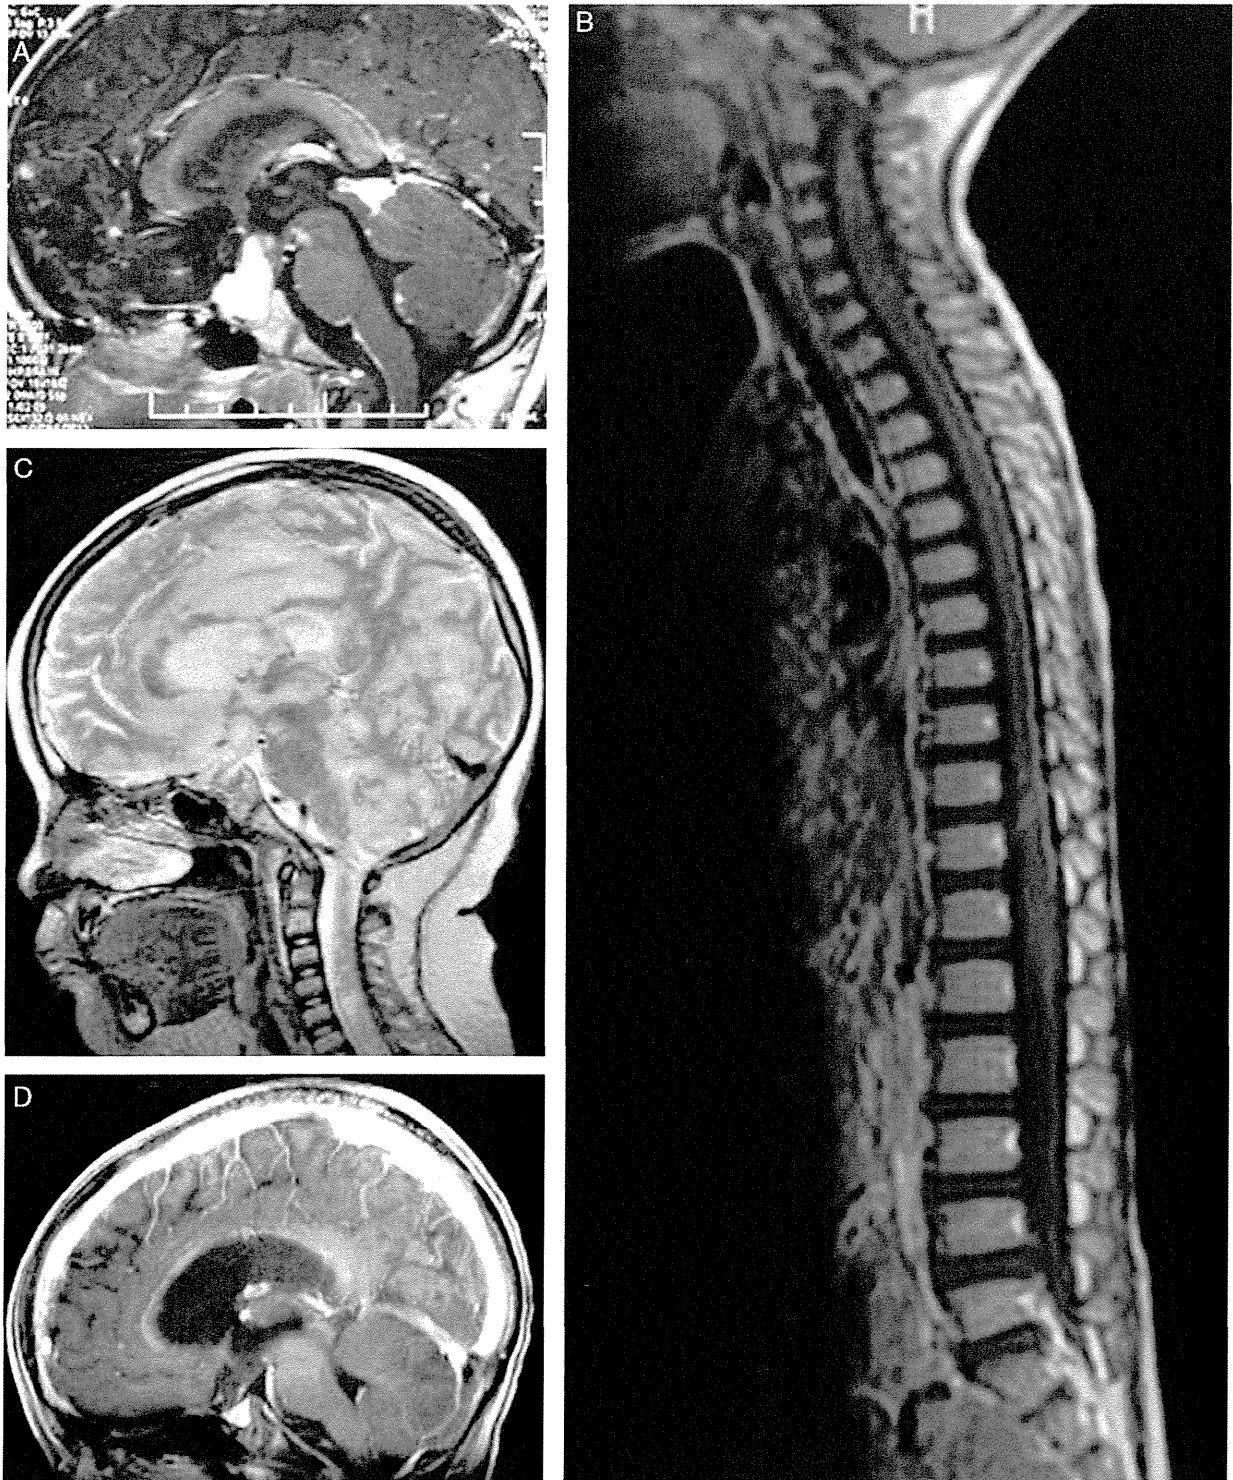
Radiographic findings: (A) Sagittal, T1-weighted, contrast-enhanced magnetic resonance imaging (MRI) taken at initial presentation of the 5-year-old patient. The optic nerve is seen to enter the enhanced portion of the tumor, and patchy, linear enhancement of the leptomeninges is visible. B, Sagittal, T1-weighted, contrast-enhanced MRI of the spine showing diffuse extramedullary gadolinium enhancement. C, Sagittal T2-weighted image after 5 cycles of maintenance chemotherapy. No enhanced lesion of the optic nerve is visible, but global growth of the T2-prolonged lesions is evident. D, Sagittal, T1-weighted, contrast-enhanced image of the patient at 7 years of age, after 3 months of maintenance temozolomide treatment. The T1-weighted contrast-enhanced lesion and T2-prolonged lesions show a complete response.
